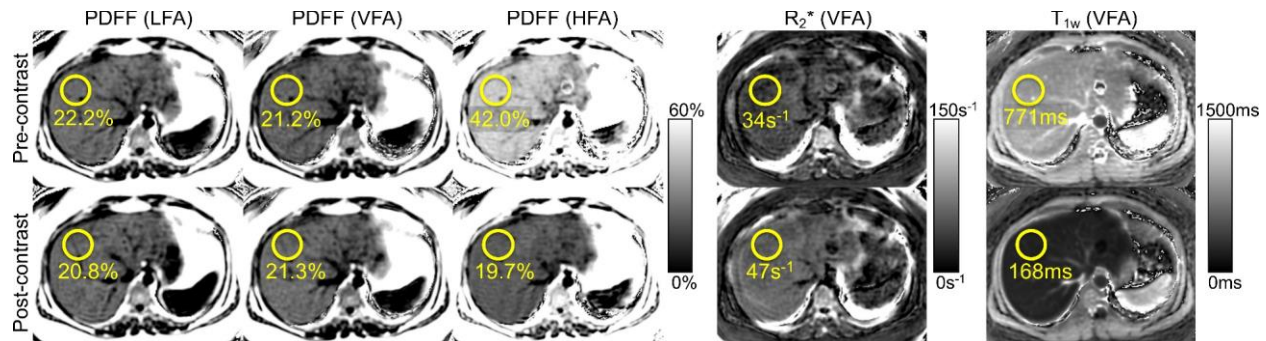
Example PDFFF, R_2^* and T_{1w} maps from a subject with elevated liver PDFFF, acquired before and after the administration of gadoxetic acid, visually demonstrating the effects of contrast on estimated PDFFF, R_2^* and T_{1w} values. In this figure, the PDFFF map and ROI value shown for LFA-CSE-MRI pre-contrast was not corrected with any T_1 assumption.
